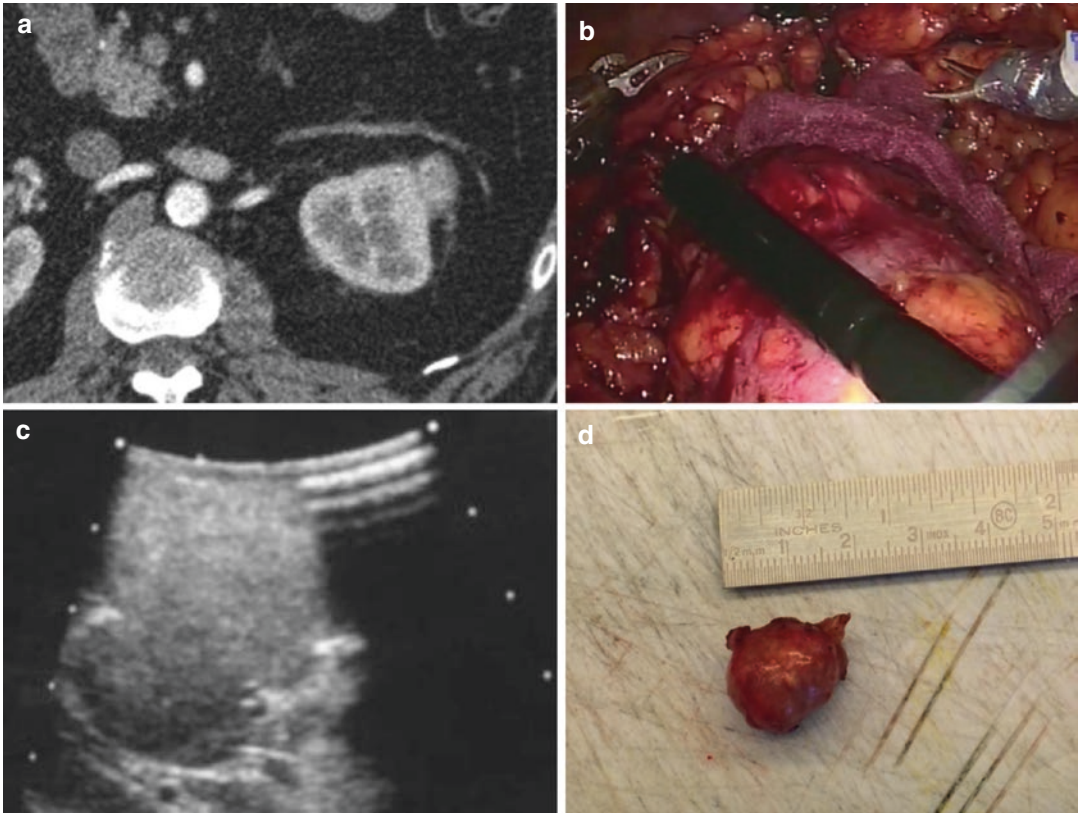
(a–d) Female patient 45 years old with solid lesion measuring 2 cm in correspondence of the middle third of the left kidney. Survey axial CT (a) demonstrates heterogeneously hypervascular lesion predominantly exophytic. During robotic enucleoresection (b)
